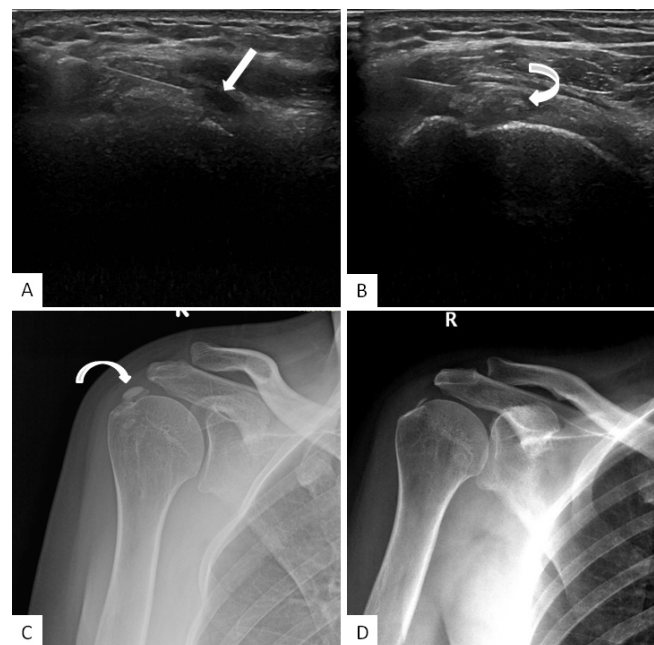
A 53-year-old, female patient. A. Coronal US examination. Tip of needle is seen within subacromial bursa (white arrows). B. Coronal US examination. Calcification is seen at supraspinatus tendon (curved arrow). C. Right shoulder, A-P roentgenogram. Supraspinatus tendon calcification prior to SAI (curved arrow). D. Right shoulder, A-P roentgenogram, sixth month control. Near-total regression of calcification
